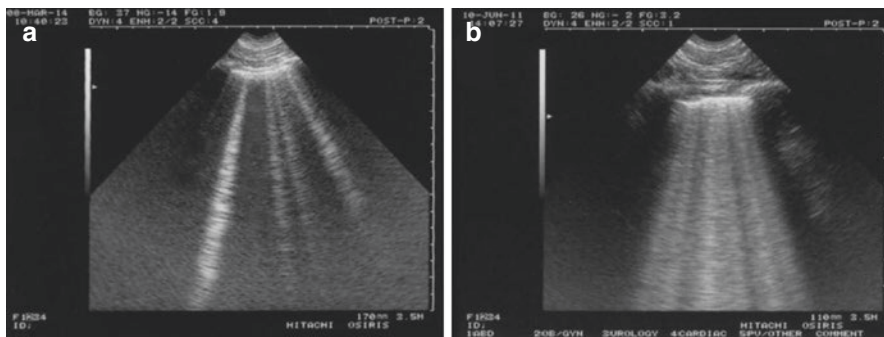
Lung ultrasound and B-lines (a, b – B-lines [17])
